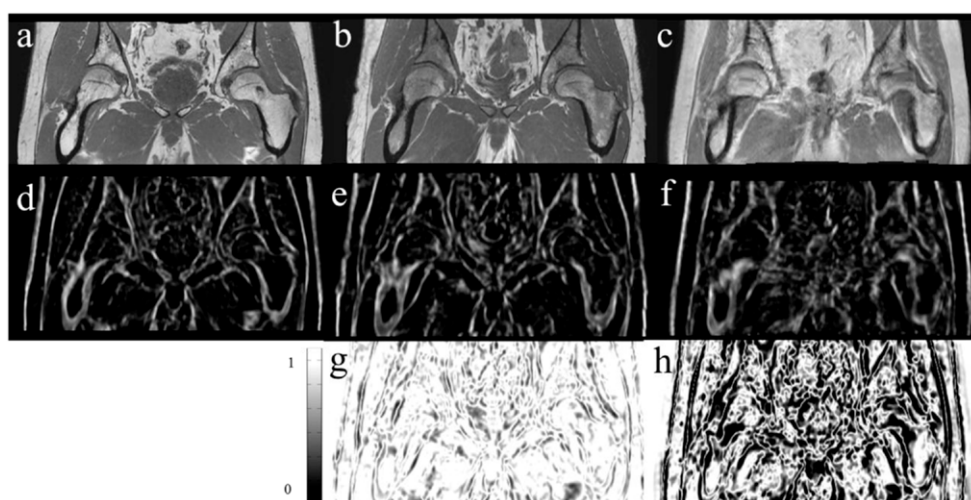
Representative slice of MR images and their corresponding PCMs. (a) Target MR image; (b) well-aligned atlas MR image; (c) poorly-aligned atlas MR image; (d) PCM of image (a); (e) PCM of image (b); (f) PCM of image (c); (g) morphology likelihood between (a) and (b) using equation (4); and (h) morphology likelihood between (a) and (c) using equation (4).
